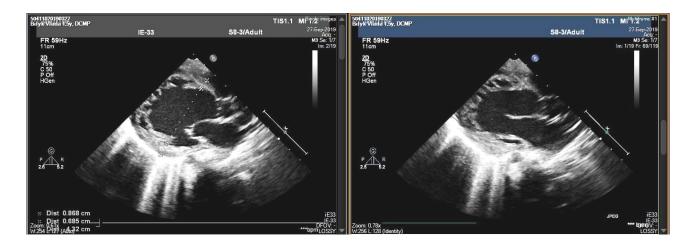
Echocardiography along the long axis of the left ventricle. Significant dilatation of the left ventricular cavity, end-diastolic size 43 mm. Non-compactness of the walls of the left ventricular myocardium
